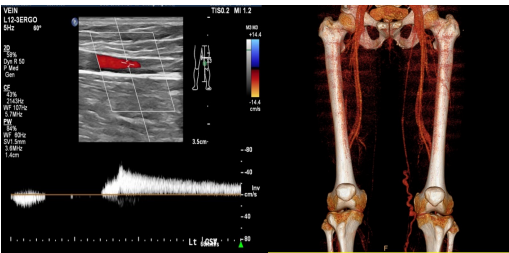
Diagnostic assessment of CVI: duplex US and CT angiography.
